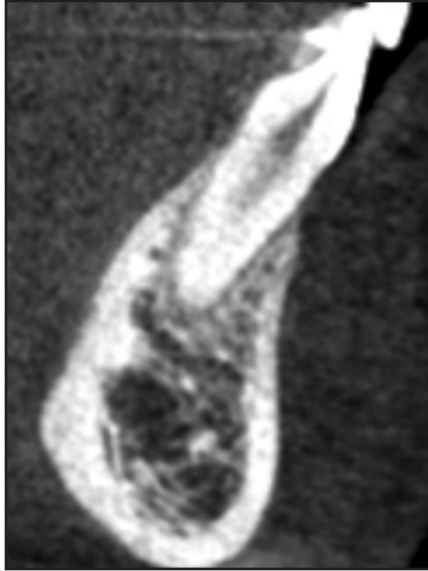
Case 1. CBCT image showing bony apposition on facial aspect of lower anterior teeth, with well-defined labial cortex.
